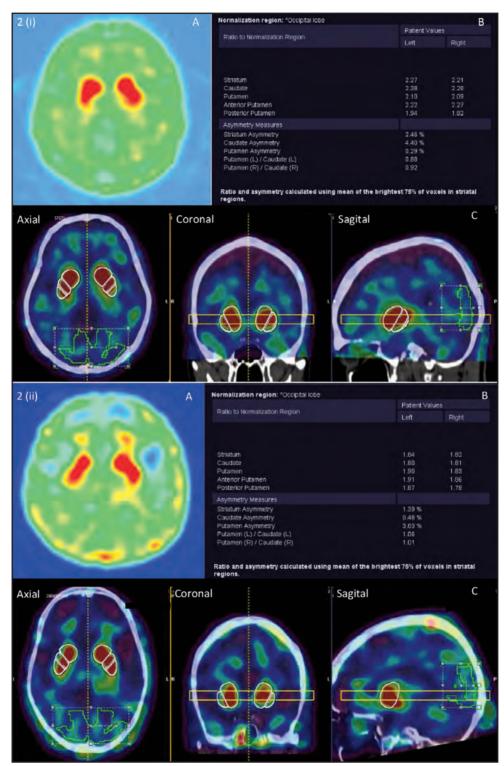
(i). Tc-99m TRODAT-1 SPECT CT images of a 60-year-old man, presented with paroxysmal head tremors for 3 years with suspected essential tremor. The patient had an inconsistent response towards Benzhexol. (A) Transaxial TRODAT-1 SPECT-CT scan showed symmetrical and normal DAT striatal binding. Both striata have comma shapes and sharp borders. (B) and (C) Semiquantitative analysis based on automated VOI was in normal ranges. This finding excludes the presence of a striatal dopaminergic deficiency and is consistent with essential tremor
